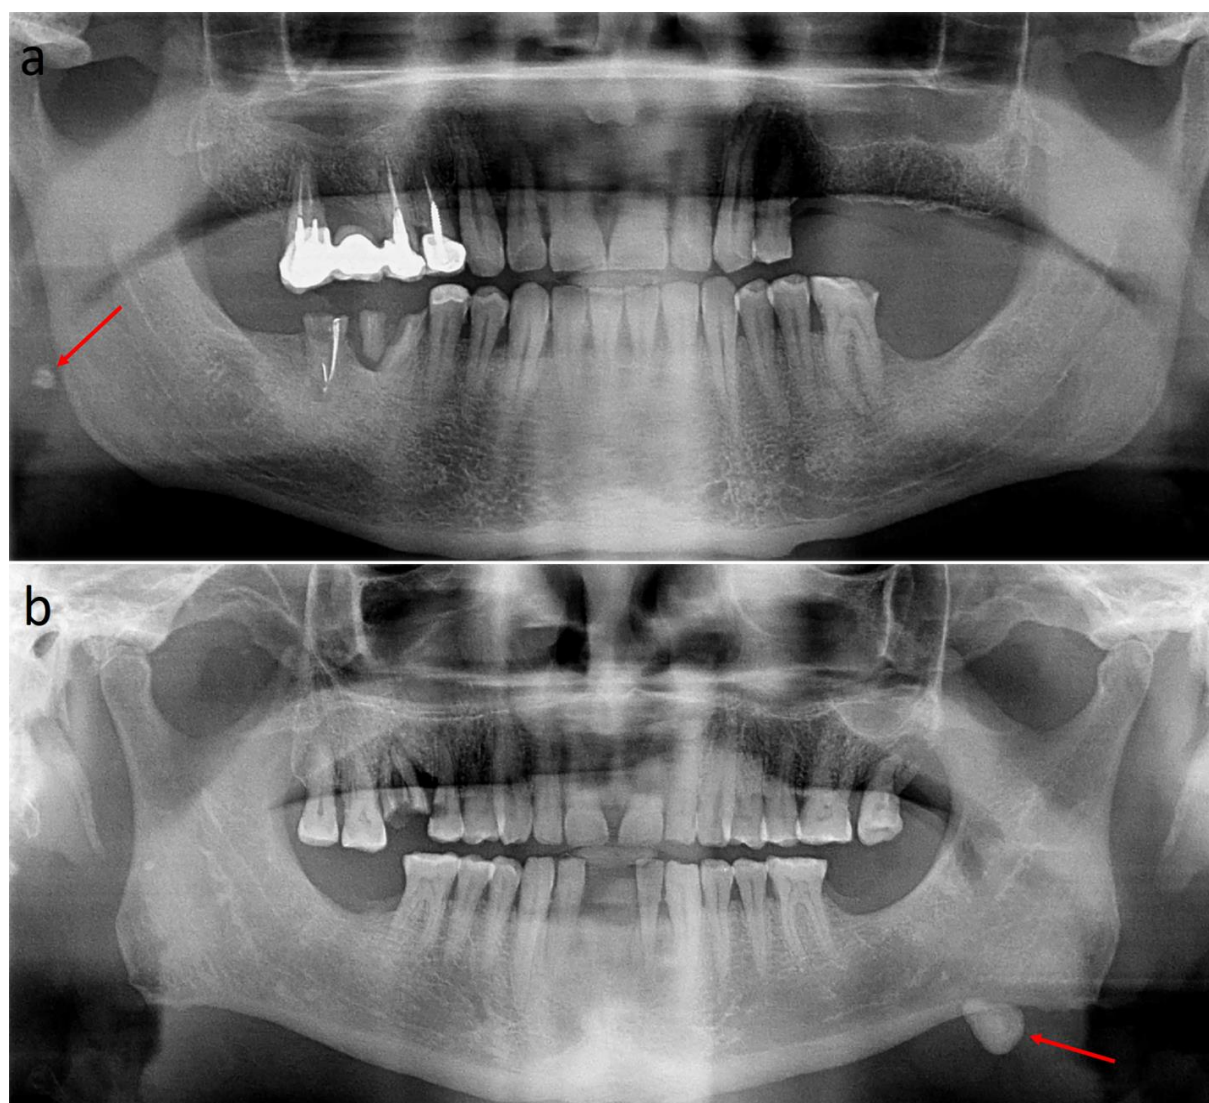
Panoramic radiographs showing parotid (a) and submandibular (b) sialoliths (red arrows)
